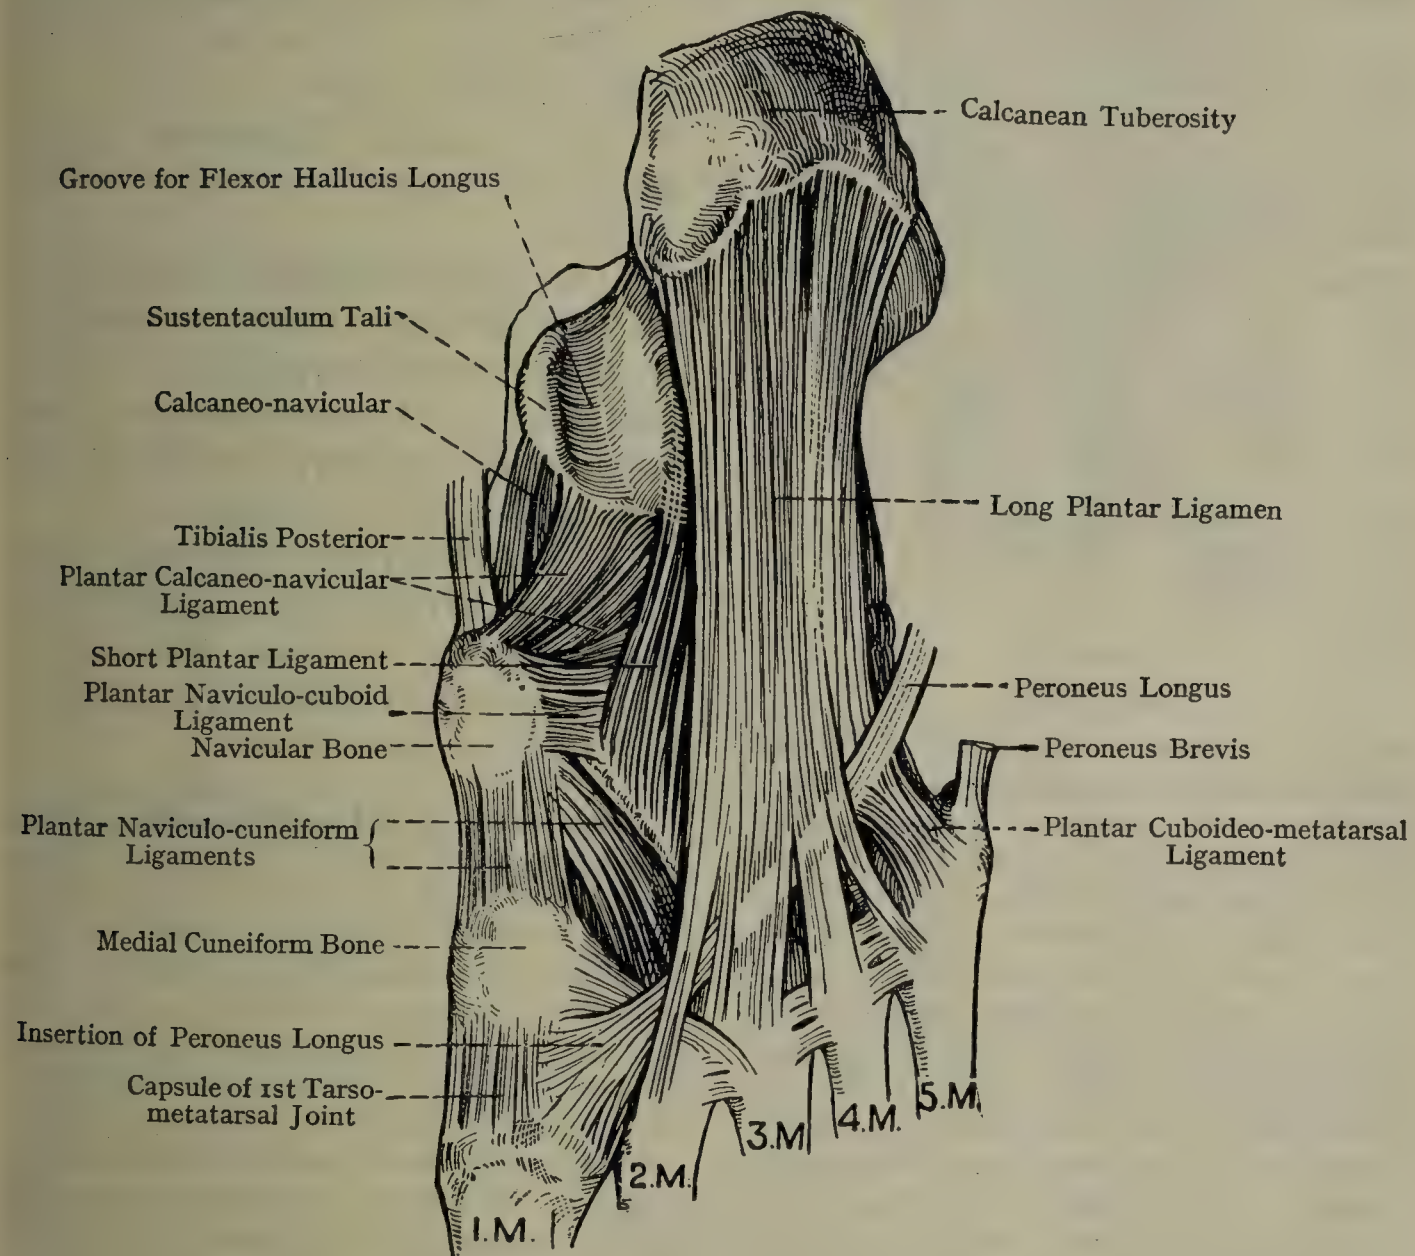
LIGAMENTS OF THE RIGHT FOOT (PLANTAR ASPECT).
